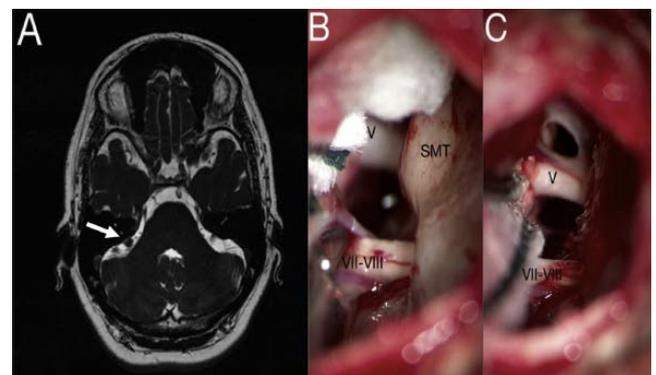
Clinical case 3: A. Fiesta sequence of the preoperative MRI showing with a white arrow an enlarged SMT type 3 B. An operative image through a right retrosigmoid approach showing the enlarged SMT obstructing the surgical corridor to decompress the trigeminal nerve completely. C. After the SMT was drilled, the trigeminal nerve is widely exposed, released of any vascular contact, and arachnoidal adhesions were thoroughly dissected; SMT: Suprameatal tubercle, V: Trigeminal nerve, VII-VIII: Seventh and Eighth cranial nerves.
